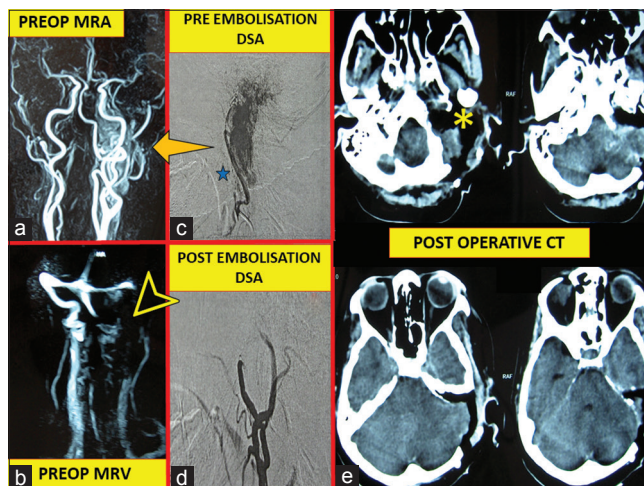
Preoperative and postoperative images of patient 1: (a) Preoperative magnetic resonance angiography showing tumor blush (arrow). (b) Magnetic resonance venography showing total obliteration of sigmoid sinus and proximal half of internal jugular vein (arrow head). (c) Preembolization digital subtraction angiography showing tumor being fed from ascending pharyngeal artery (star). (d) Postembolization digital subtraction angiography showing no tumor blush. (e) Postoperative computed tomography showing near-total petrosectomy (asterisk) with total excision of the lesion
